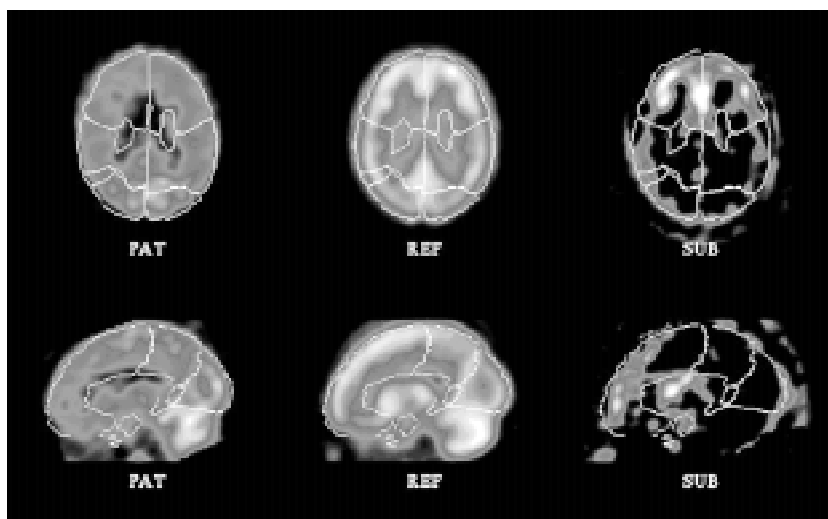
Inter-subject comparison. 76-year-old man, with symptoms of dementia since 10 yr admitted to the hospital for syncope attacks. The SPECT scan is consistent with a diagnosis of Frontal Lobe Dementia. The decreased tracer uptake in frontal lobes is highlighted by the subtraction image (SUB), obtained by subtracting the patient's image (PAT) from the reference image (REF). This latter is the average of 12 age matched controls. The two sets of data have been standardised into a common CBA space. The colour scale is in arbitrary units.
